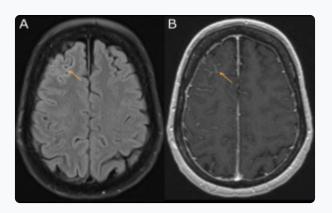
Cortical oedema in FLAIR hyperintensity (A, orange arrow). Leptomeningeal enhancement in T1 post-gadolinium injection sequence (B, orange arrow).
